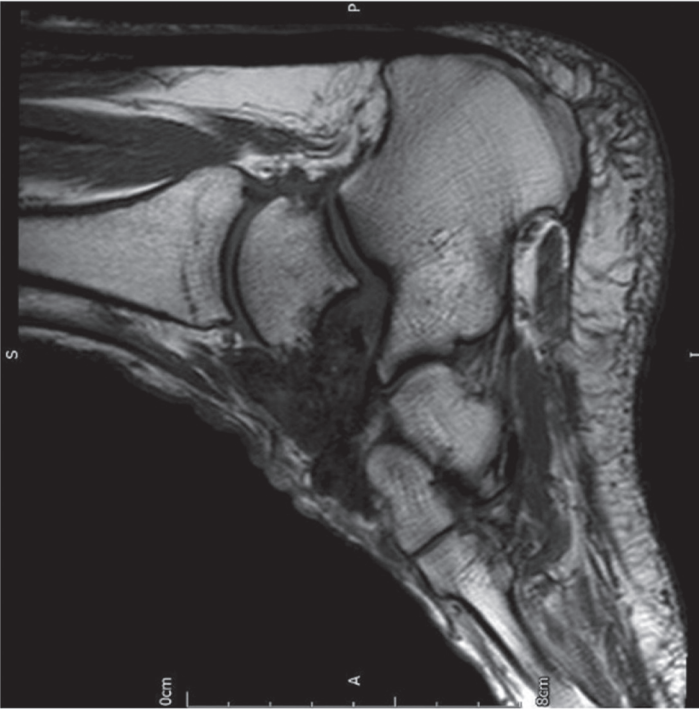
Sagittal T2 MRI image showing a well-circumscribed lesion in the subarticular joint, presenting localised-type TGCT.*
